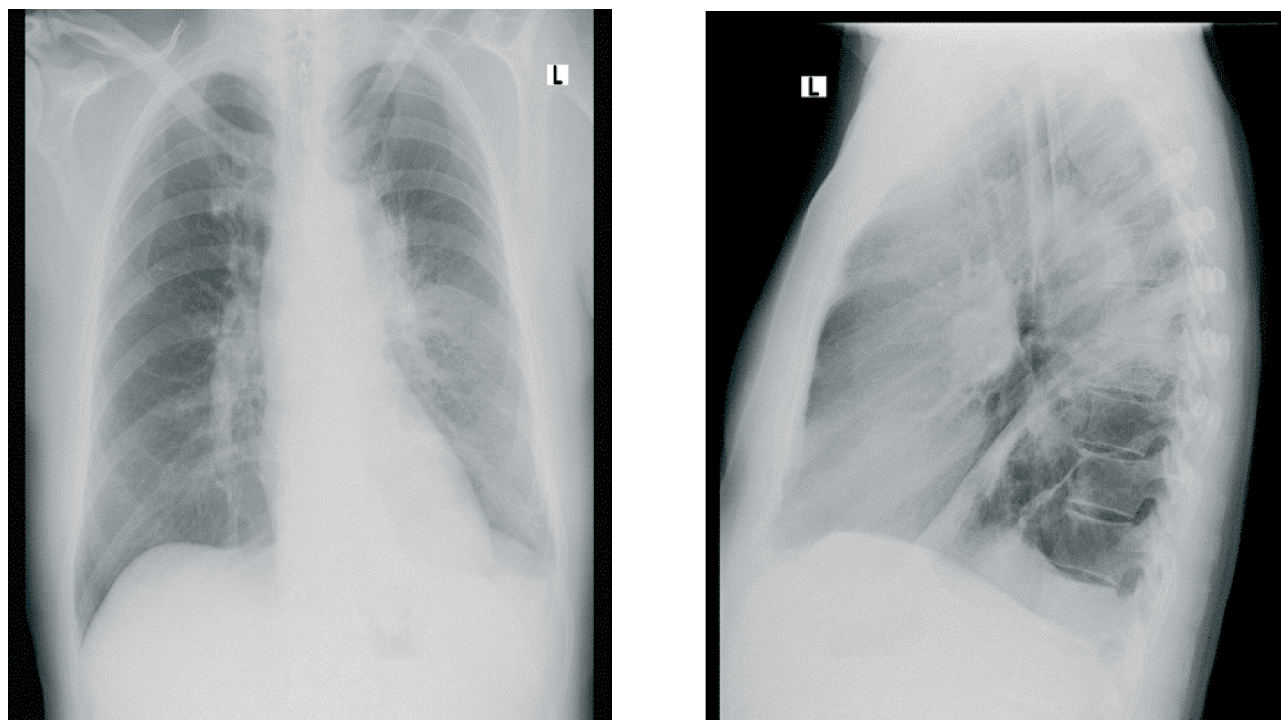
Chest X-ray after 10 days of treatment. Progression of the density of the left lobe infiltrate and a pleural effusion of the left lung base, measuring approx. 4.5 cm
